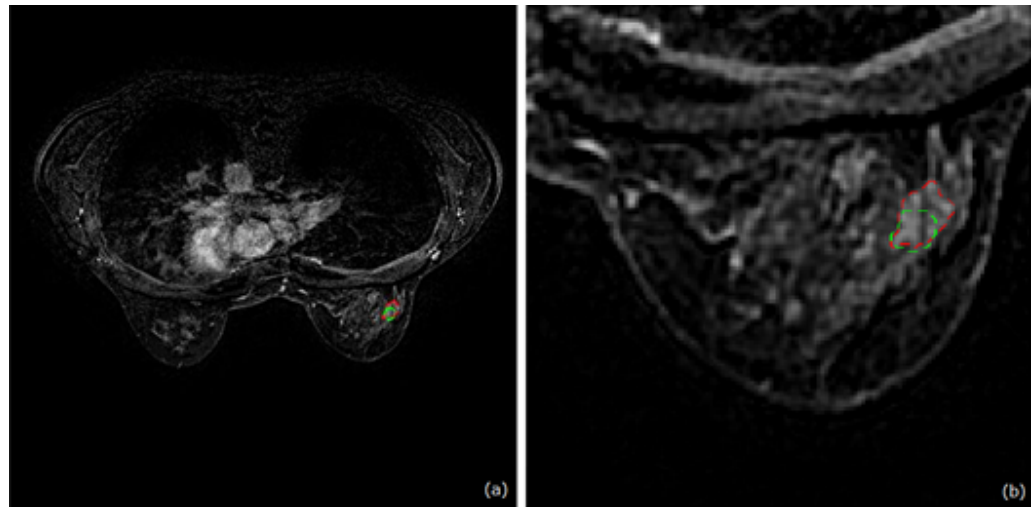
Case with a low-contrast lesion: (a) entire axial DCE-MRI slice; (b) crop of the slice shown in (a). Comparison between manual ground-truth (green) and automatic segmentation (red).
